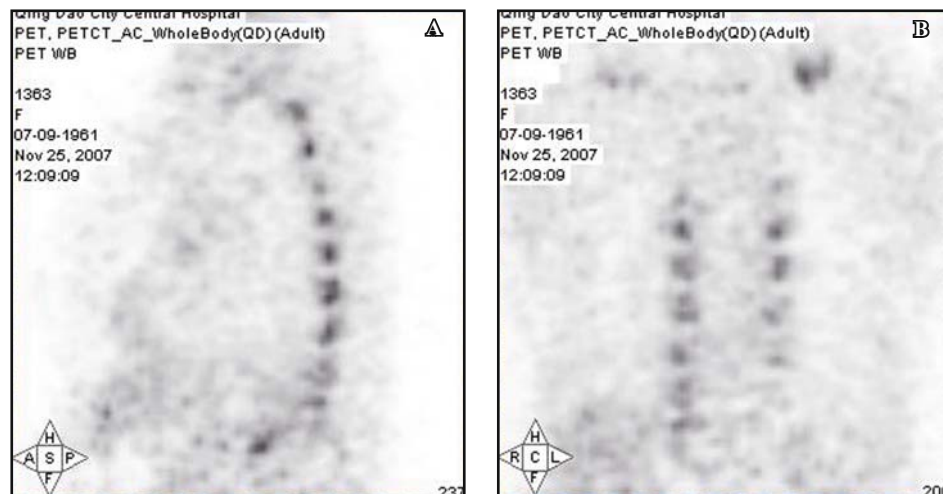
Sagittal slice (A) and coronal slice (B) show foci of ^{18}F -FDG activity along the thoracic spine bilaterally, mapped to the paravertebral intercostal space.
